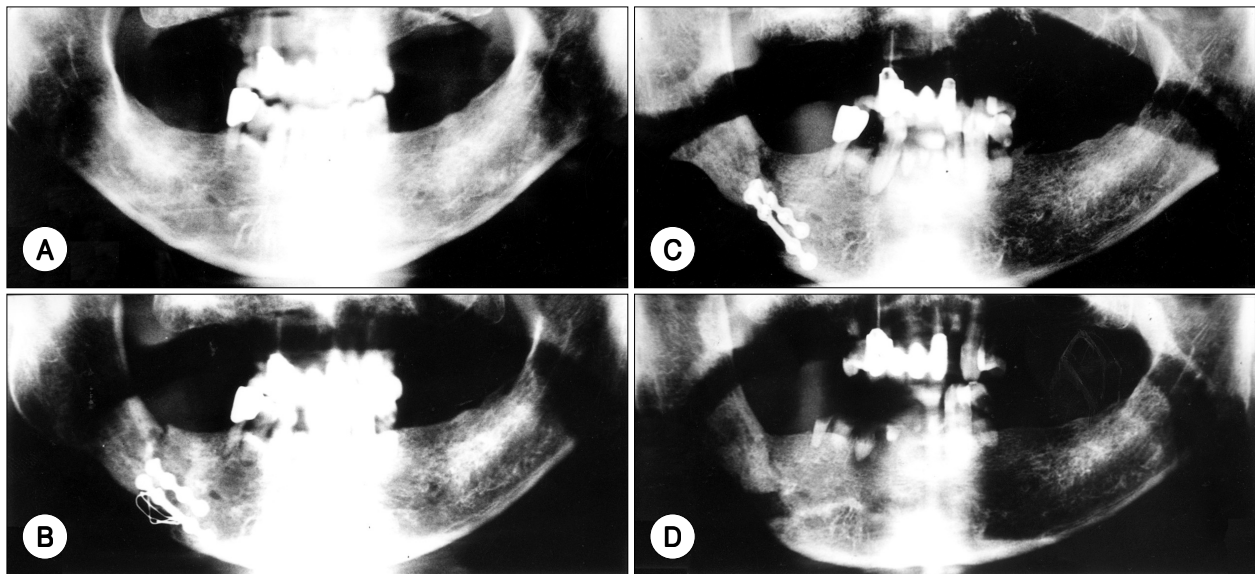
Radiographic (Panex) sequences of osteoradionecrosis in case 3. Osteoradionecrosis occurred at osteotomy site 7 months following radiotherapy (5400 cGy) which was done 3 months after surgery with lateral mandibulotomy and sagittal partial mandibulectomy for right tonsillar cancer. A : Preoperative. B : POD 10 months (time of diagnosis of osteoradionecrosis)-The Panex showed nonunion and irregular bony defect. Sequestrectomy and wire removal were done with HBOT. C : POD 18 months-Necrotic bony gap narrowed slightly but inferior bony resorption was aggravated at 8 months after surgery. Second operation was done for removal of the plate. D : POD 43 months-Osteoradionecrosis was completely healed showing new bone formation. POD ; postoperative HBOT ; hyperbaric oxygen therapy.
